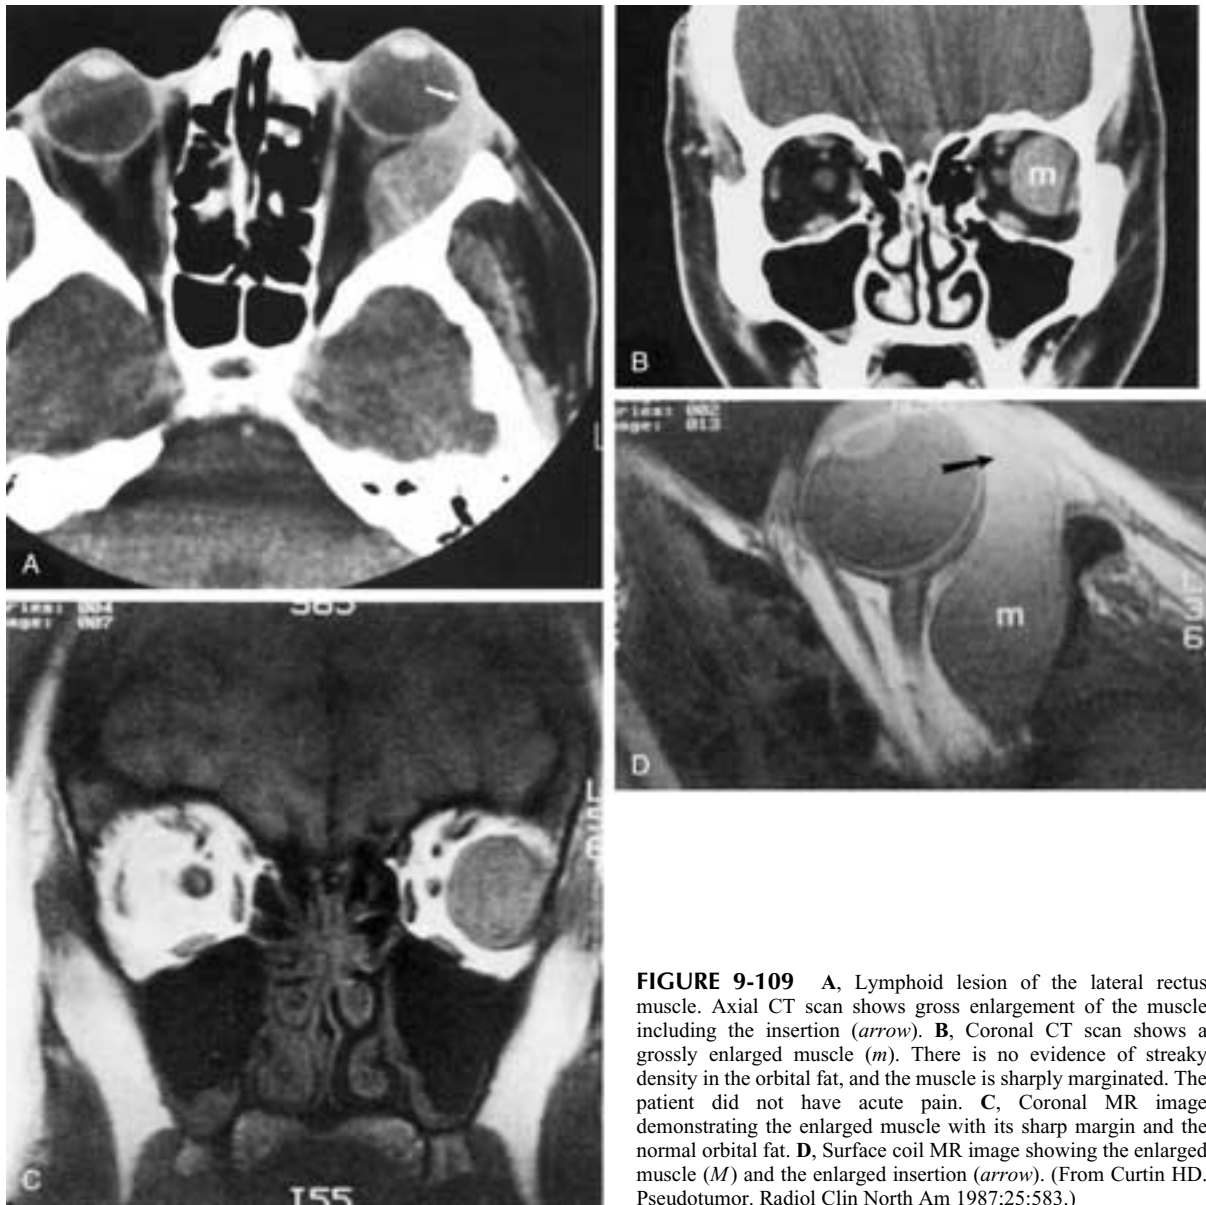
A, Lymphoid lesion of the lateral rectus muscle. Axial CT scan shows gross enlargement of the muscle including the insertion (*arrow*). B, Coronal CT scan shows a grossly enlarged muscle (*m*). There is no evidence of streaky density in the orbital fat, and the muscle is sharply margined. The patient did not have acute pain. C, Coronal MR image demonstrating the enlarged muscle with its sharp margin and the normal orbital fat. D, Surface coil MR image showing the enlarged muscle (*M*) and the enlarged insertion (*arrow*). (From Curtin HD. Pseudotumor. *Radiol Clin North Am* 1987;25:583.)
